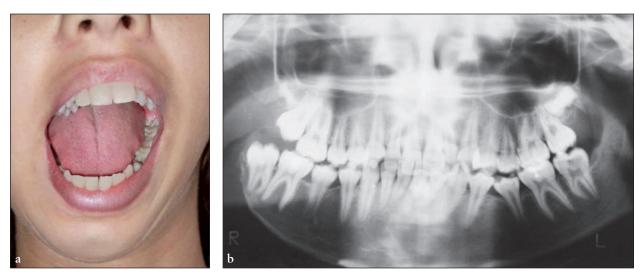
(a) Clinical and (b) radiographic aspects of the patient at 3.5 years follow-up.
